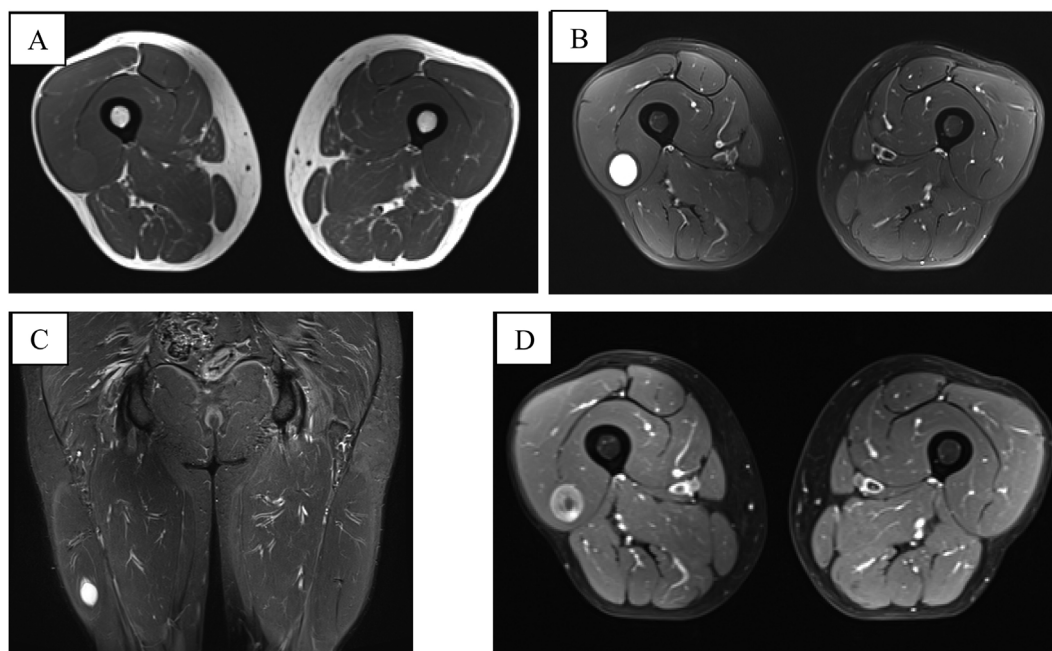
MRI of thighs: (A) intensity similar to the musculature in T1 sequences, without fat suppression; (B and C) high intensity in PD sequences with fat suppression showing cranial and caudal halo; (D) peripheral heterogenous moderate-intense enhancement with hypointense nodular central area and no enhancement in T1 post-contrast.
